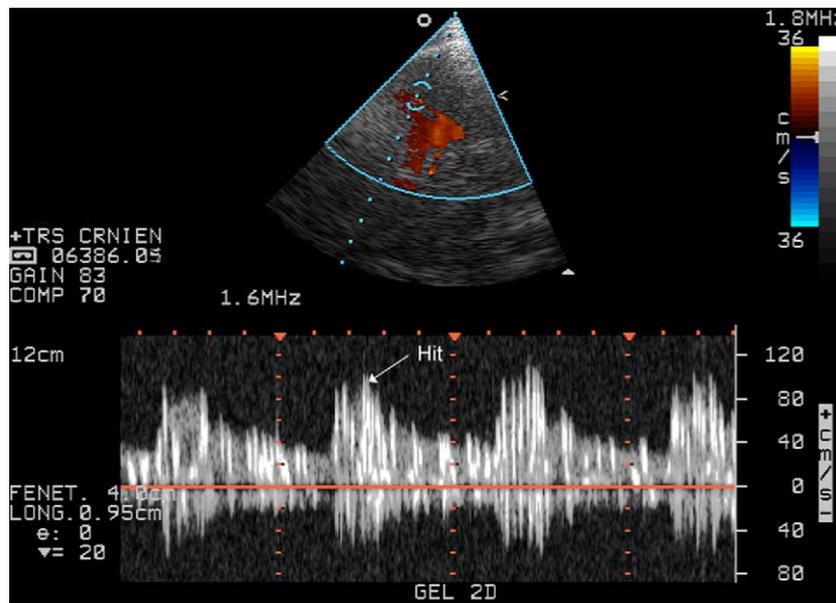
Medium shunt with transcranial Doppler.
